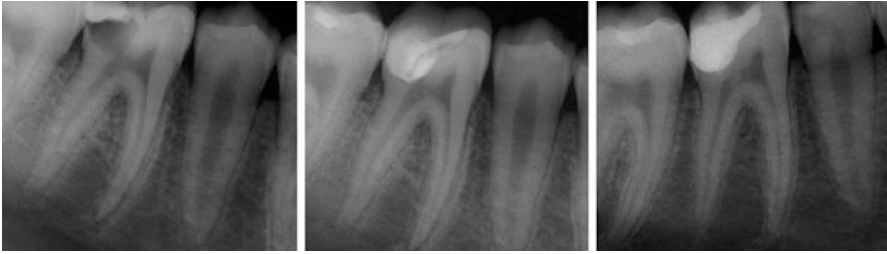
(Left) Preoperative radiograph of a 12-year-old child showing first mandibular molar with extremely deep caries. (Middle) After excavation and carious exposure and MTA application. (Right): Postoperative 1-year follow-up. Tooth vitality present and well-defined *lamina dura* in the apical region. Note the formation of tertiary dentin (Courtesy of Dr. G. Bogen)
